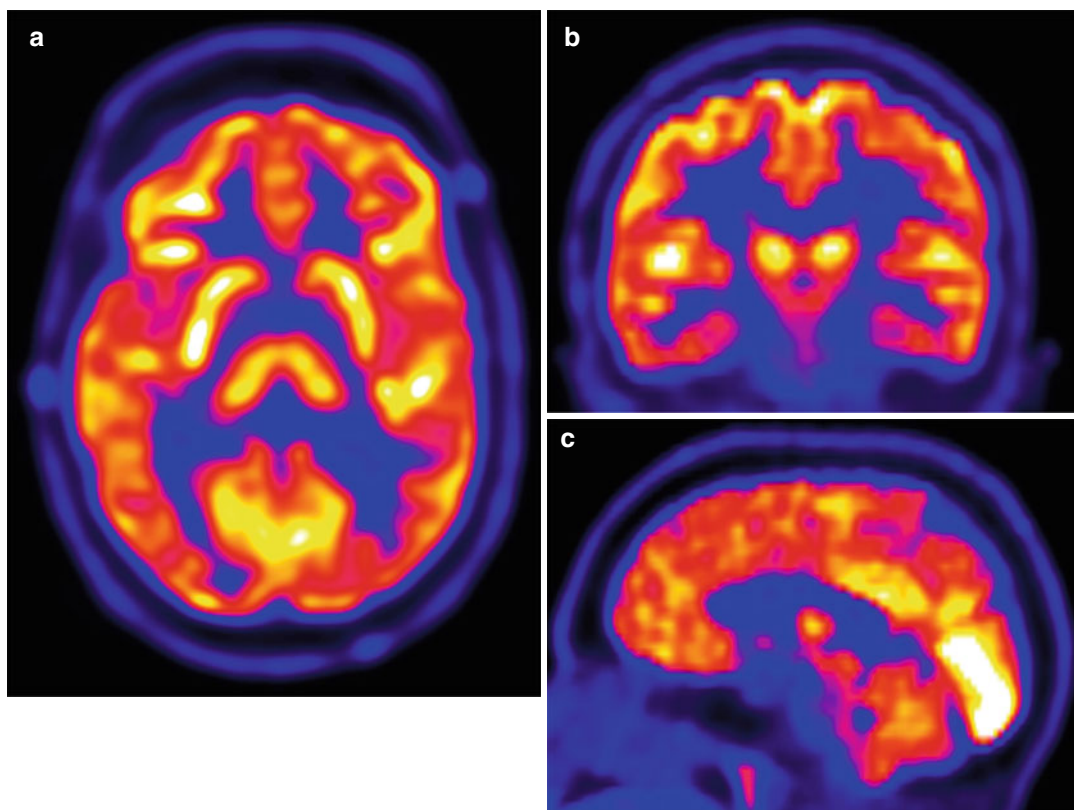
Brain ^{18}F -FDG PET in a 16-year-old male. A brain ^{18}F -FDG PET displayed in axial (a), coronal (b), and sagittal (c) planes demonstrates the normal pattern of ^{18}F -FDG uptake in the brain. Within the cerebral cortex, physiological uptake of ^{18}F -FDG is greater in the gray
